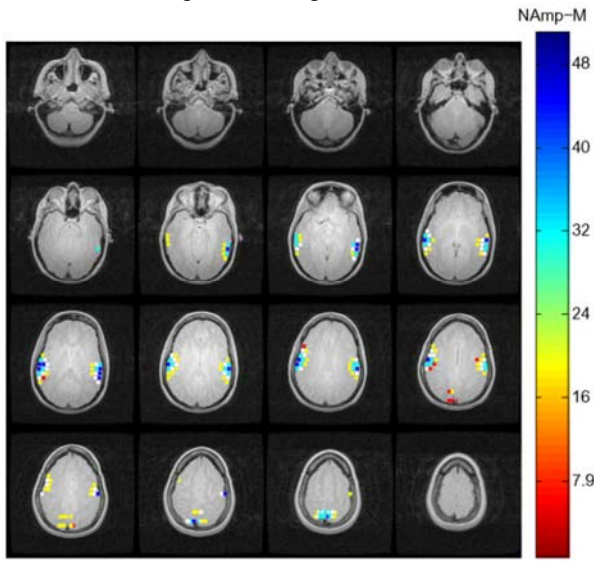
MEG detected activations of subject #2 after co-registration to the 3-D anatomical MRI data.
